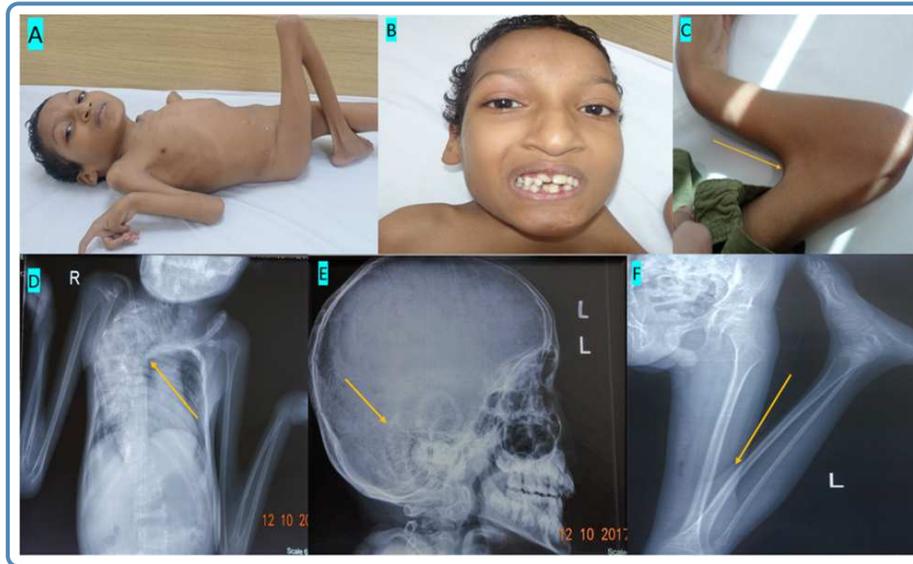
A) Showing child affected with Bruck syndrome with multiple flexion contractures involving both upper and lower limbs B) Showing overcrowded malformed teeth C) Elbow with pterygium and contractures D) Radiograph of the thorax (anteroposterior view) showing severe kyphoscoliotic deformity of the dorsolumbar spine and vertebra plana at L3 E) Radiograph of the skull showing Wormian bones with a small sella and protruding mandible F) Radiograph of the left lower limb showing flexion contracture of the knee and the ankle joint.
